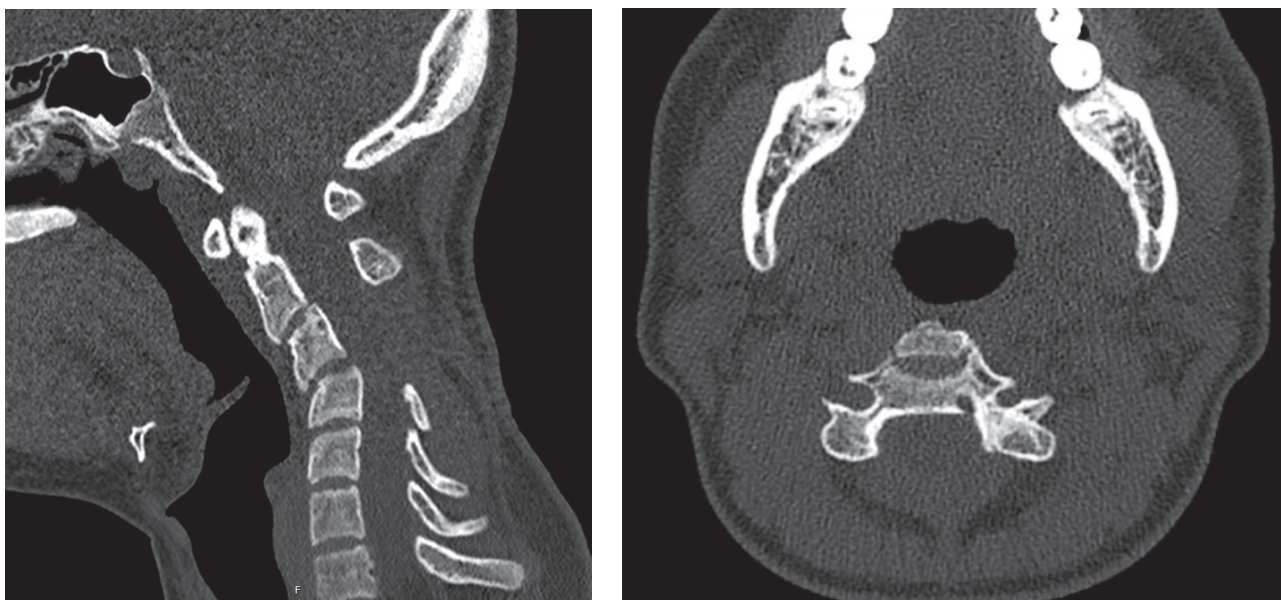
a) Control CT scan after six months showed substantial progression of the cervical kyphosis and b) no residual cyst progression was seen in the left dorsal part of the C3 vertebra body.
